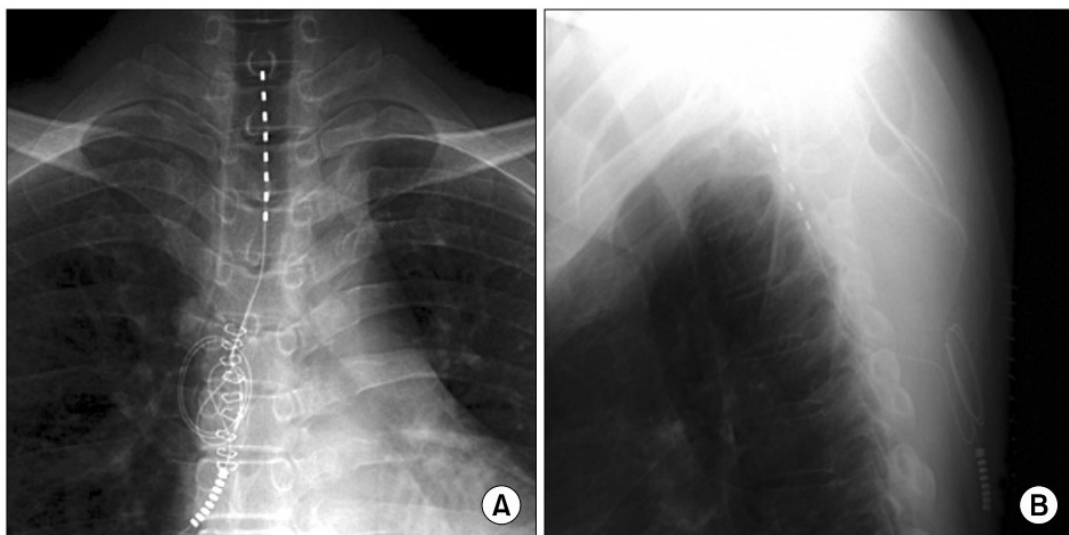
X-ray demonstrating the position of implanted thoracic SCS electrodes in a refractory angina patient (A) AP projection and (B) lateral projection (Lee, 2012).
